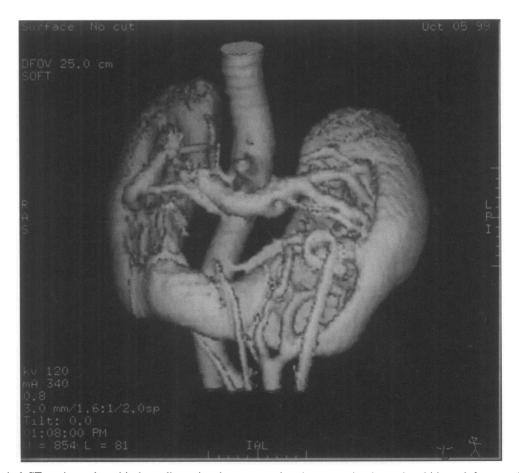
Spiral CT angiography with three-dimensional reconstruction demonstrating horseshoe kidney, left ureteral stent, and no anterior crossing vessels. Stone is not seen clearly in this image but is present.
